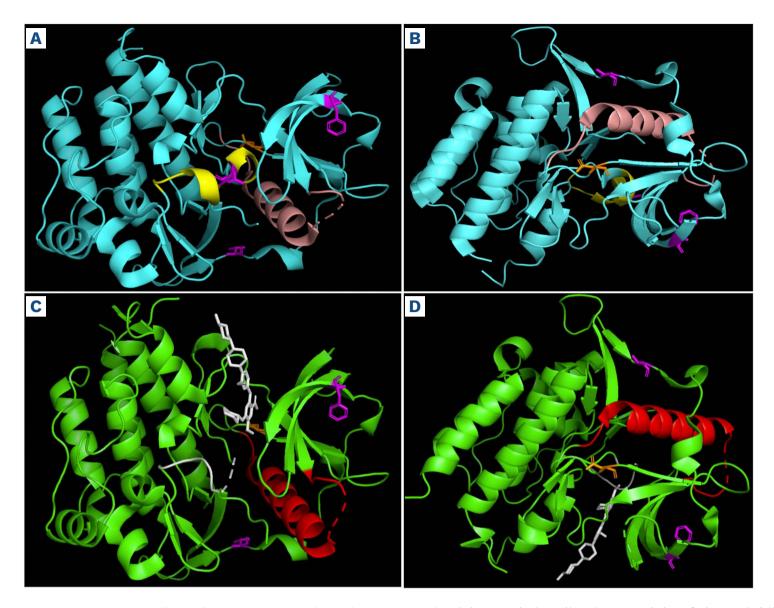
Macromolecular modeling of the FLT3 tyrosine kinase domain. (A) PyMol visualization models of the uninhibited FLT3 tyrosine kinase domain with N676K (residue shown in orange) and activation loop (yellow). Residues F612 and D835 (corresponding to internal tandem duplication and tyrosine kinase domain mutations, respectively) are shown in magenta. (B) Upon activation, the 18-fluoro-deoxyglucose (FDG)-containing α helix (salmon) translocates inward. Inhibition by gilteritinib at the ATP-binding site is depicted in the inactive, FDG-out (C) and activated, FDG-in (D) state with the FDG-containing α helix shown in red.
